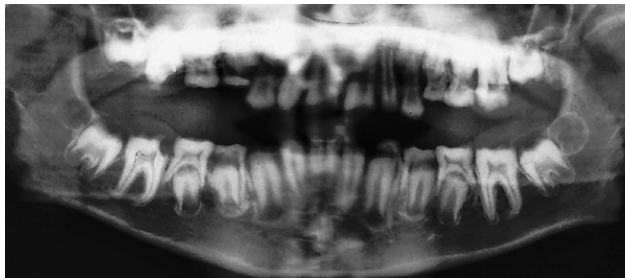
Panoramic radiograph of the patient. Note the unerupted permanent molars, with the maxillary first molars appearing externally resorbed.
